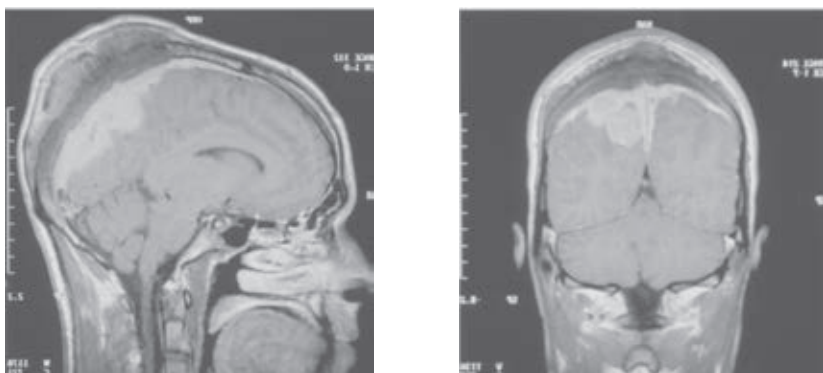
Preoperative sagittal (left) and coronal (right) T1-weighted MR-image after intravenous gadolinium.
